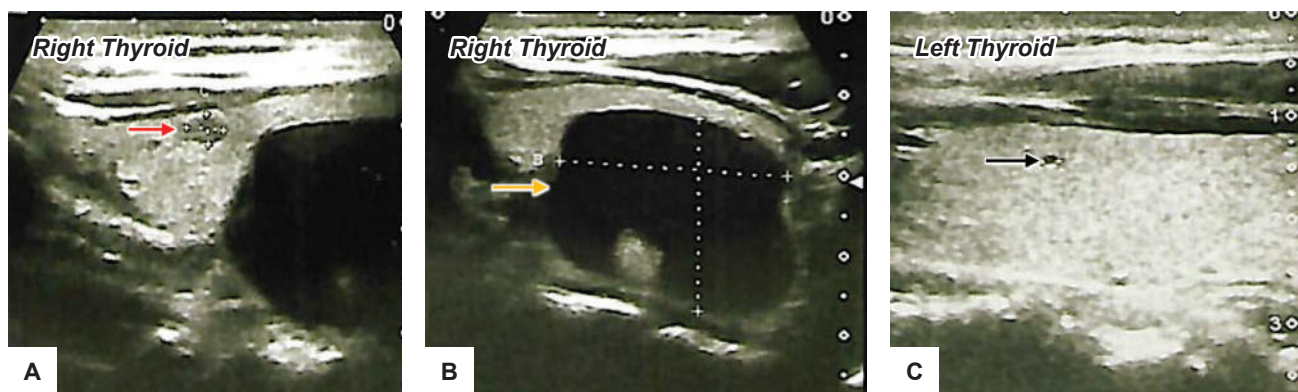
(A) Ultrasound shows a 0.58 cm solid mass (red arrow); (B) shows a 3.08 x 2.82 x 2.11 cm ovoid cystic mass (yellow arrow) both located at the right thyroid lobe; (C) shows a 0.21 cm ovoid cyst (black arrow) at left thyroid lobe.
